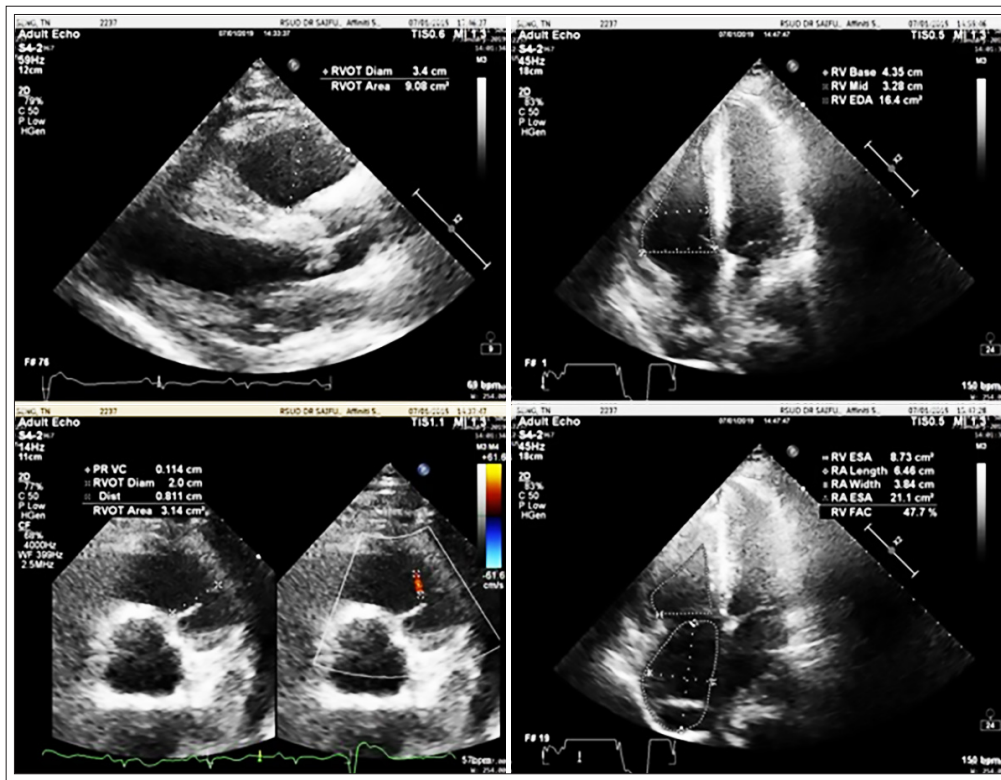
Echocardiography supported the minor criteria of ARVC diagnosis. Note the dilatation of RV and RV FAC 47.7%
